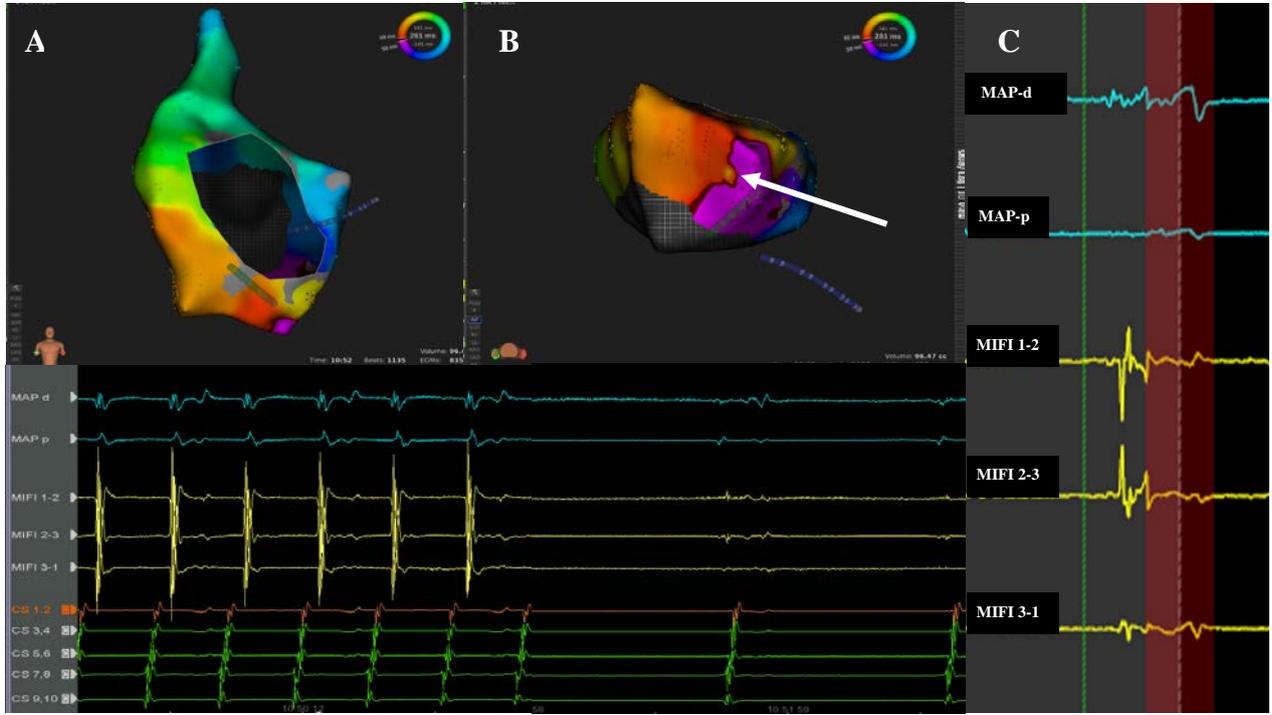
A and B: electroanatomical map of the tachycardia (AP and AP tilted-up view of the right atrium), on RHYTHMIA™ mapping system. C: the local signals on the IntellaNav MiFi™ XP ablation catheter on the CTI before ablation. A linear radiofrequency application (70W, 65°C) at the CT isthmus terminated the tachycardia (white arrow, panel D). MAP-d: local electrograms on the distal dipole of the ablation catheter; MAP-p: local electrograms on the proximal dipole; MIFI 1-2, MIFI 2-3 and MIFI 3-1: local EGMs on the mini-electrode dipoles (IntellaNav MiFi™ ablation catheter); CS: local EGMs on 10-poles catheter in coronary sinus.
